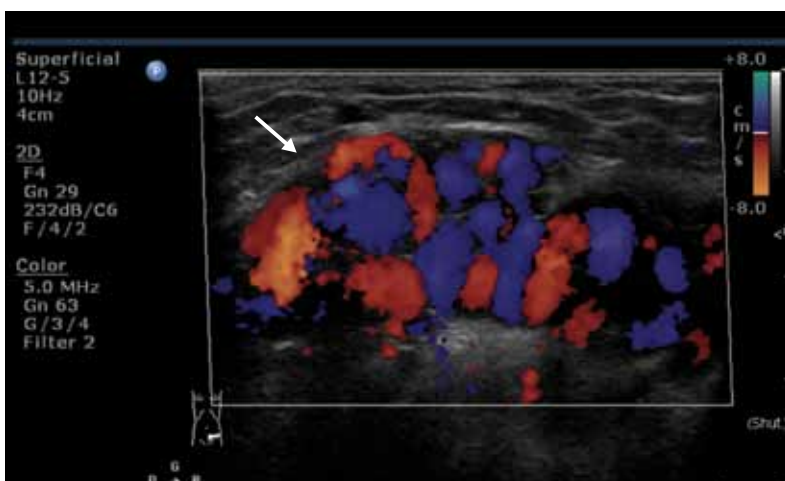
Vascular flow in round ligament varicosity (arrow) is demonstrated on colour Doppler study
